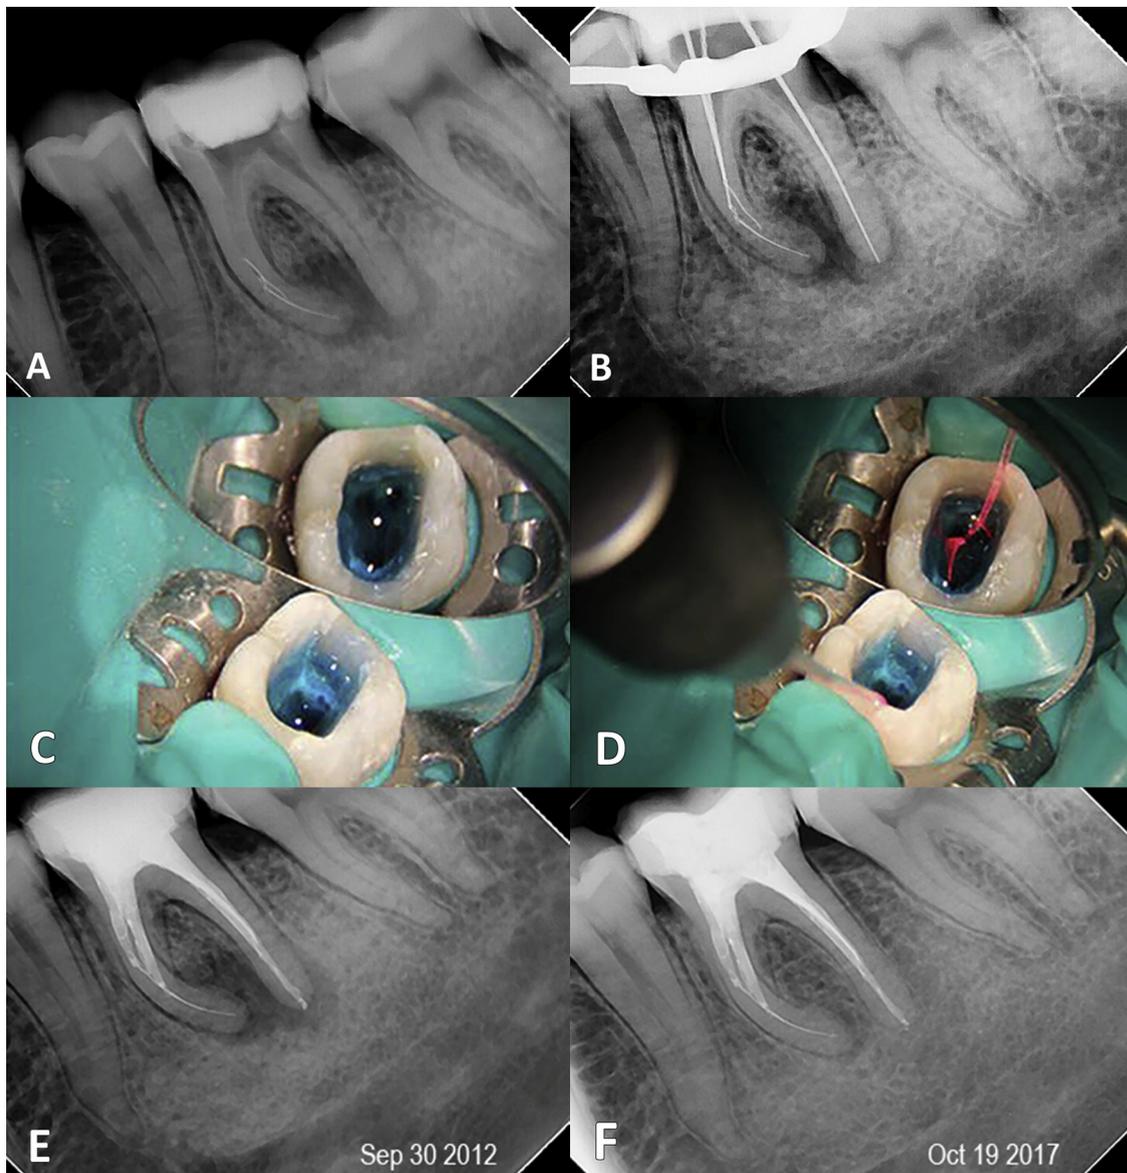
Radiograph revealed a periapical lesion and two separated files within the mesial root and Attempt at bypassing the separated instrument (A and B). Irrigation with methylene blue solution 0.005% (C). A 300- $\mu$ m light diffuser was inserted into the root canals (D). Post-op radiograph (E). Follow-up after 5 years (F).
